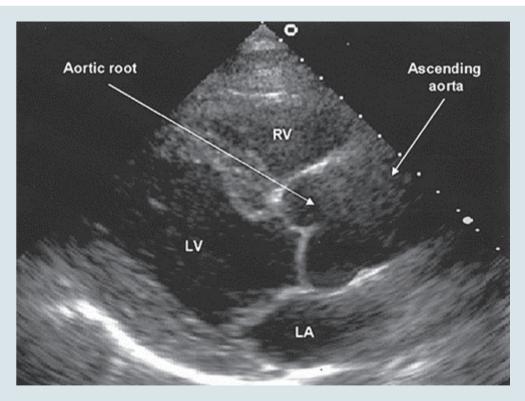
A transthoracic echocardiogram, in a parasternal long-axis view, demonstrating a dilated aortic root (4.4 cm) and ascending aorta (4.2 cm). Whereas the aortic root is well visualized, the ascending aorta is less so, as is often the case with transthoracic imaging. RV – indicates right ventricle; LV – left ventricle; LA – left atrium
